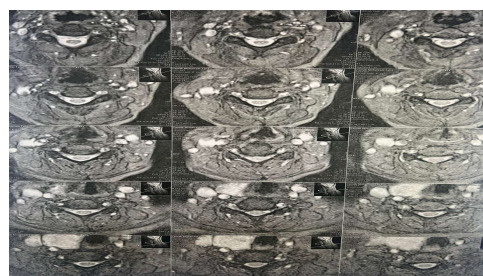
Case 5 Preoperative T2 MRI transverse view of cervical vertebrae
